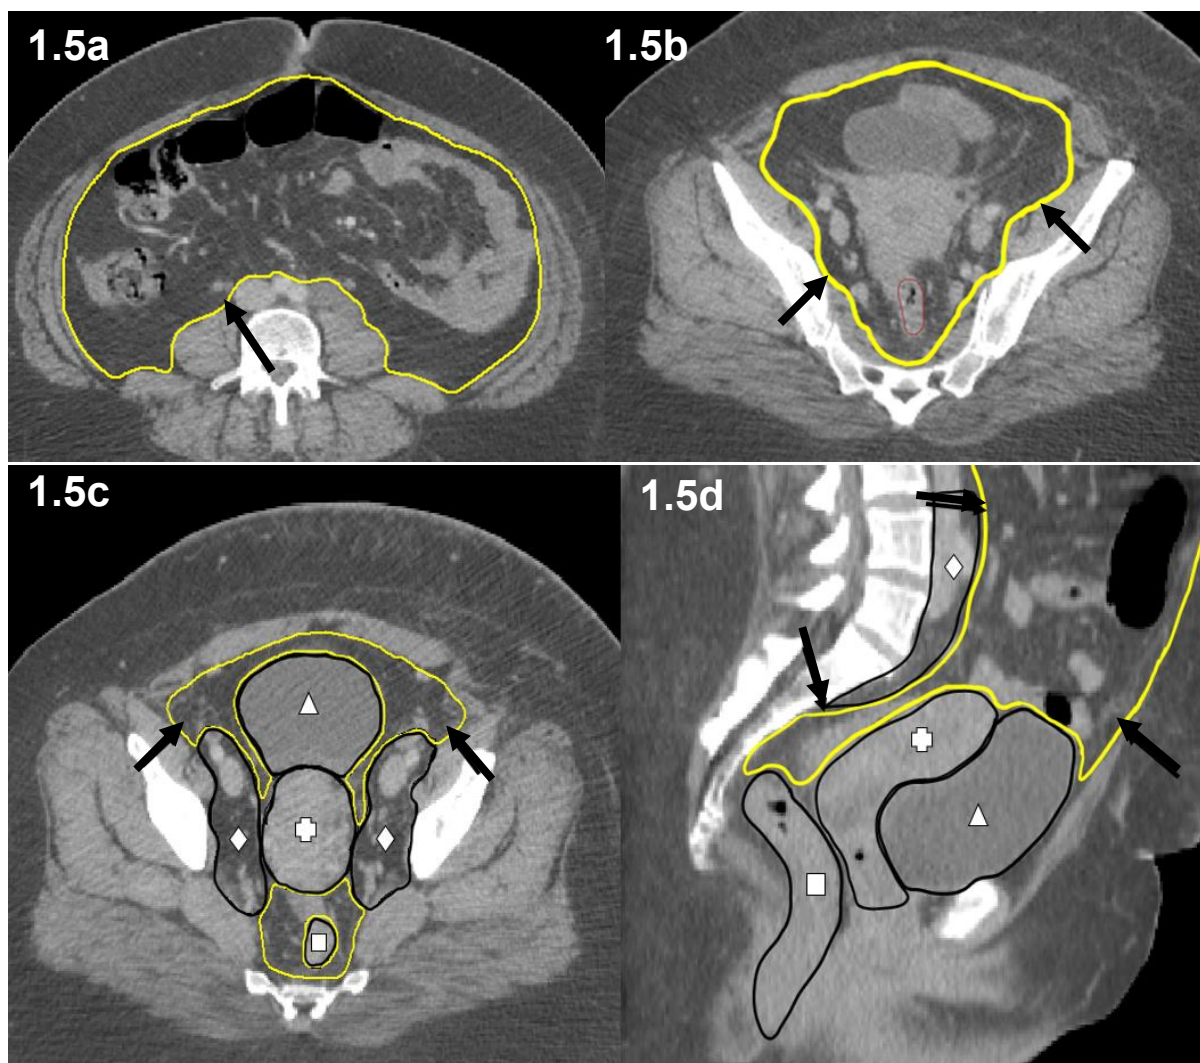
Transverse (a, b and c) and sagittal (d) CT with bowel bag outlined (arrowed) and bladder (triangle on c and d), rectum (square c and d), uterus/CTV1 (cross on c and d) and CTV2 (diamond on c) edited out of the initial volume seen in c and d.
